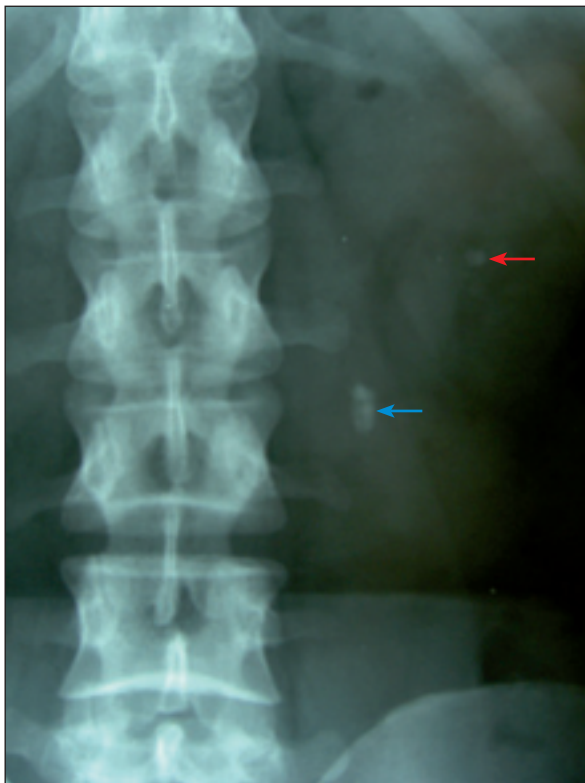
Kidney-ureter-bladder X-ray showing a radio-opacity (blue arrow) between the transverse processes of the second and third lumbar (L2–L3) vertebrae in the line of the left ureter. Also note a radio-opacity in the lower pole of the left kidney (red arrow) in this patient who had recurrent episodes of renal (ureteric) colic.
